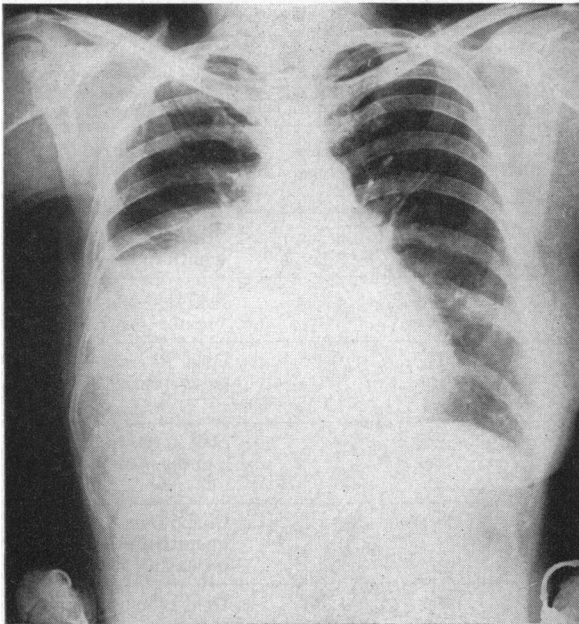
Preoperative x-ray film of chest (Case 1). Note large pleural effusion on the right.
